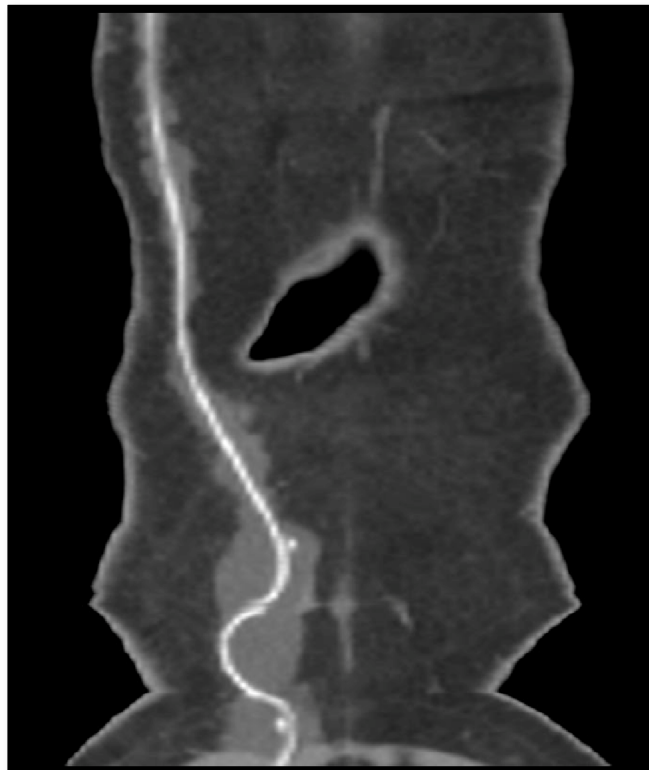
Contrast-enhanced abdominopelvic CT scan coronal reformate image shows the course of the catheter surrounded by the pseudocysts formation.
